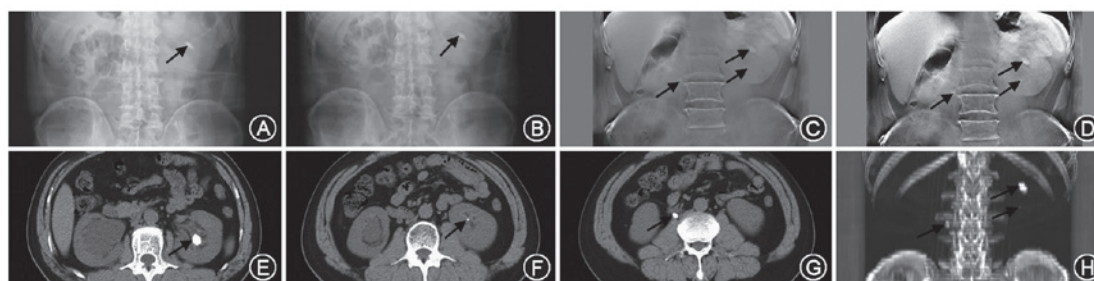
UMDCT, CT and DTS images coupled with KUB radiographs of a 55-year-old male patient, diagnosed with urinary tract calculi. KUB detected a left kidney calculus (A) prior to and (B) following bowel preparation (black arrows). DTS detected a right ureter and left kidney calculus (C) prior to and (D) following bowel preparation (black arrows). (E) CT images detected a calculus in the upper portion of the left kidney (black arrow). (F) CT images detected a calculus in the lower portion of the left kidney (black arrow). (G) CT images detected a right ureteral calculus (black arrow). (H) MIP reconstruction image of UMDCT identified a left kidney and a left ureteral calculus (black arrows). UMDCT, unenhanced multidetector computed tomography; CT, computed tomography; DTS, digital tomosynthesis; KUB, kidneys-ureters-bladder.
